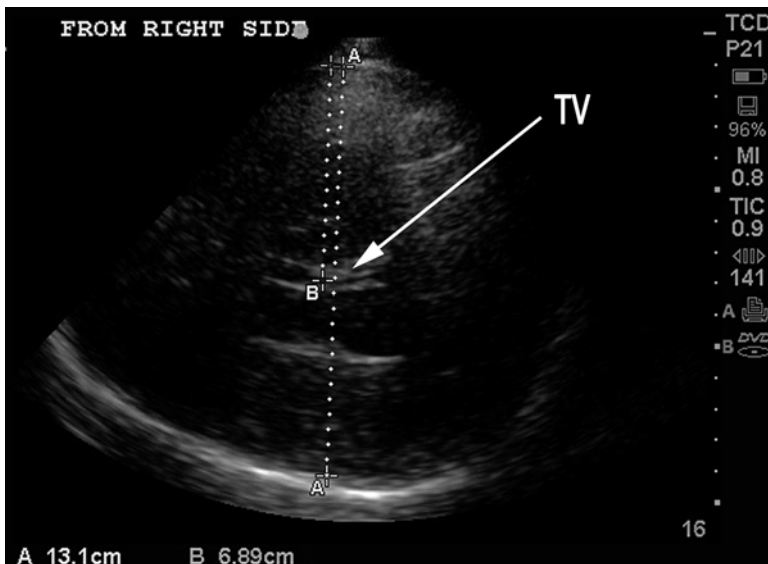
B-mode measurement of midline shift – measurement from *right*. Patient with large right MCA infarction. Third ventricle (TV) is identified by the presence of the hyperechoic *double line* (“tram track”) of the choroid plexus and marks the midline. Distance from surface to TV is 6.89 cm from the *right* and (see Fig. 15.21) 6.19 cm from the *left*. Midline shift is therefore $(6.89 - 6.19)/2 = 0.35$ cm, almost identical to the midline shift measured on CT (see Fig. 15.22)
